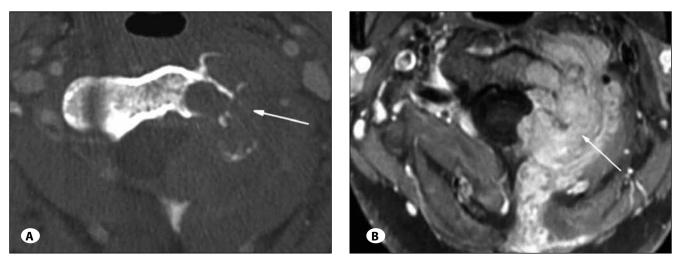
A) Preoperative computed tomography images show bone destruction on the odontoid, the C2 left vertebral body, and the left accessories of C1–2. B) A lobulated tumor mass with obvious gadolinium (Gd)-DTPA enhancement was observed on T1-weighted magnetic resonances images with intravenous Gd-DTPA administration.
